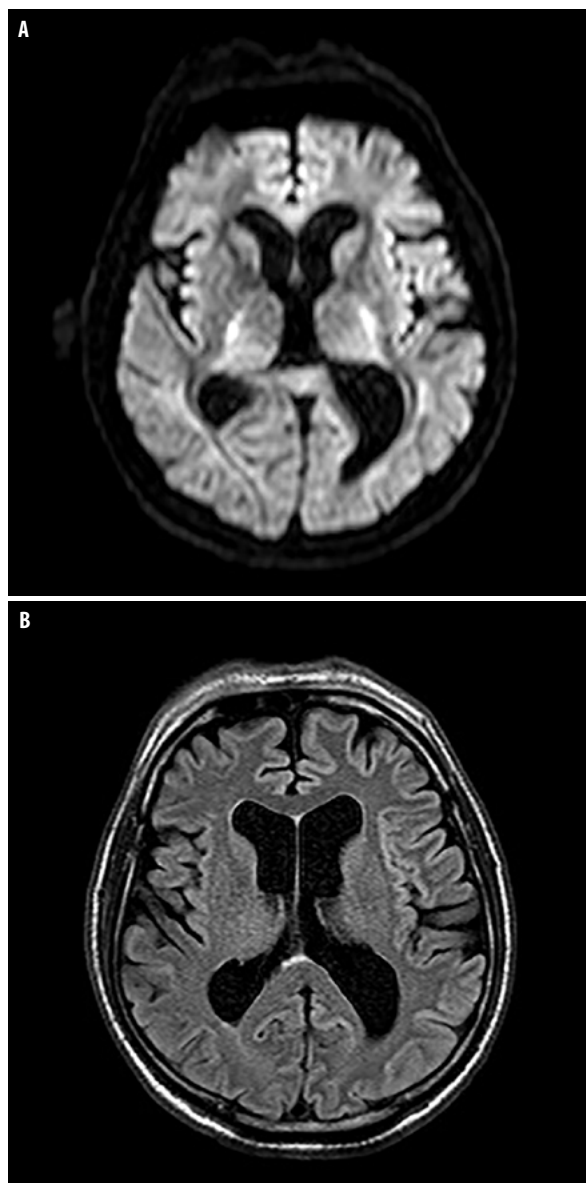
Brain MRI with DWI sequence performed after the recurrence of aphasia and onset of right-sided paresis revealed no marked hyperintensity on DWI (A) or reduced ADC values. Also, no ischaemic lesions were found in the FLAIR sequence (B)
